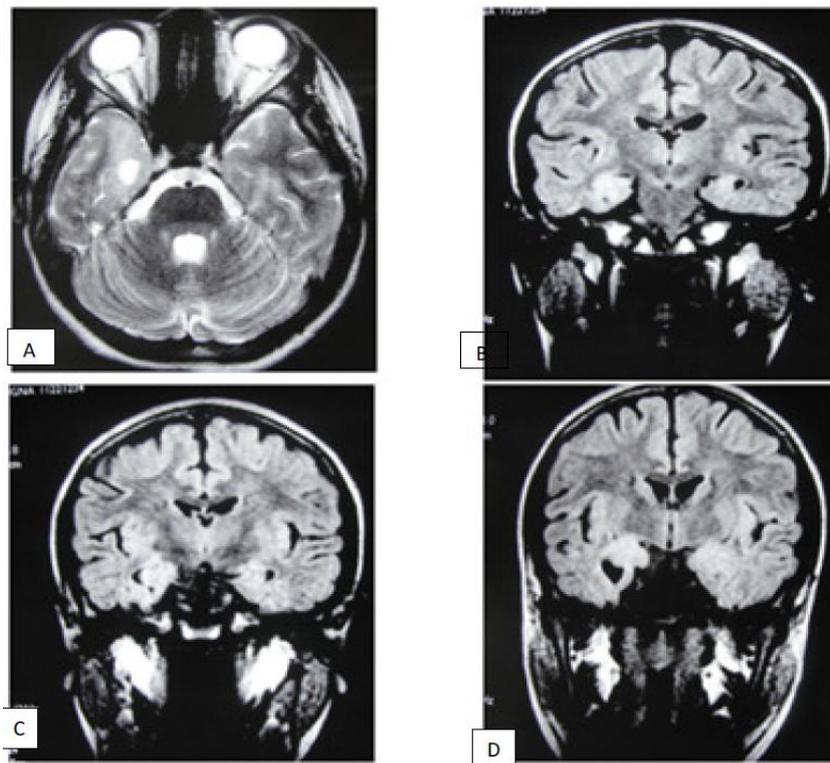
MRI different sequences A -Axial T2 weighted image, B-D coronal flair images showing right sided mesial temporal sclerosis
